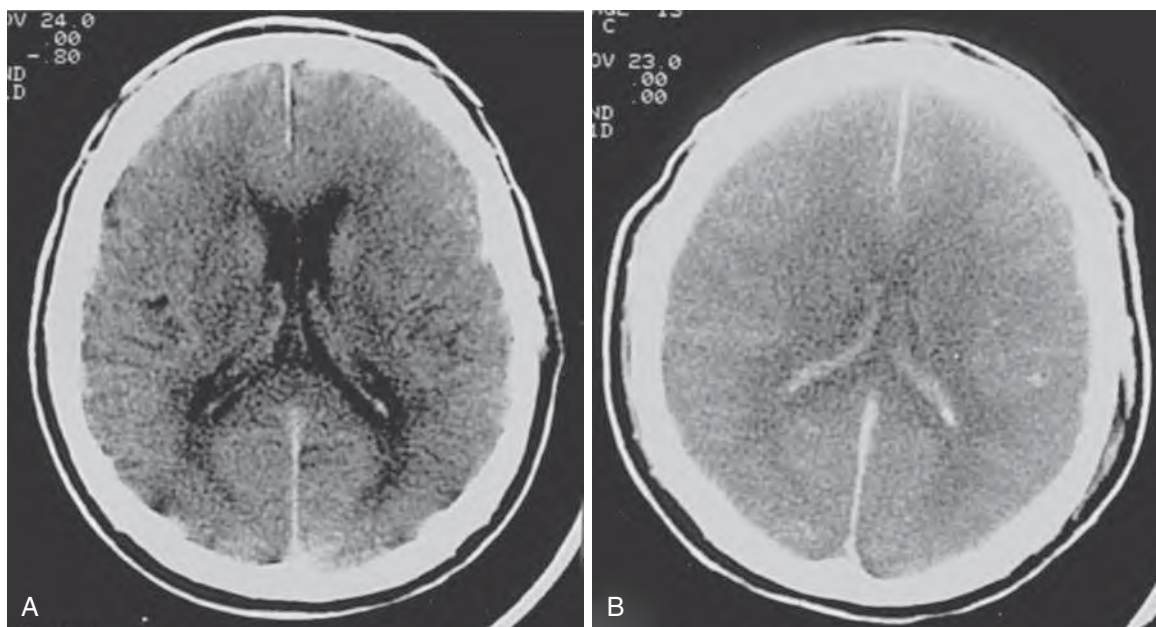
Computed tomography (CT) scans of the head in a patient with pneumococcal meningitis. (A) CT scan on presentation reveals moderate cortical atrophy. (B) CT scan 3 days later reveals diffuse swelling of the cerebral hemispheres bilaterally, with effacement of the ventricular system.
